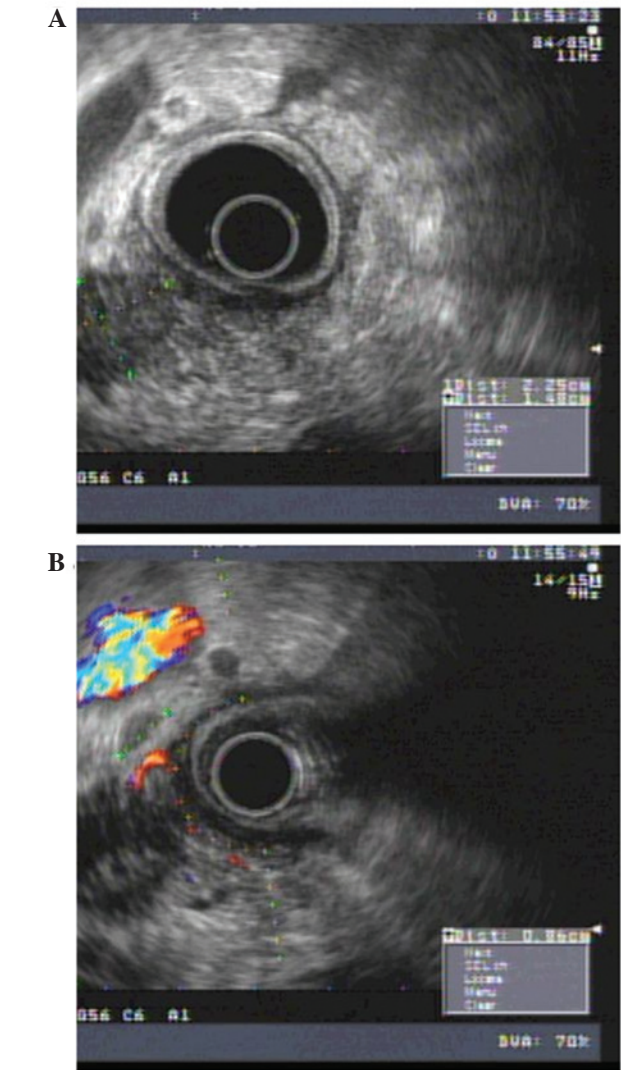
Endoscopic ultrasound (EUS) was suggestive of pancreatic cancer preoperatively because the ultrasonographic features of mass-forming focal chronic pancreatitis (MFP) are similar to those of pancreatic carcinoma and could not be absolutely excluded. Under EUS, the pancreatic body and tail were observed to be significantly narrowed (diameter <1 cm). (A) There was a low echo lesion at the head of pancreas (2.3x1.5 cm), breaking through the pancreatic envelope, and (B) a 1.1 cm enlarged lymph node.
